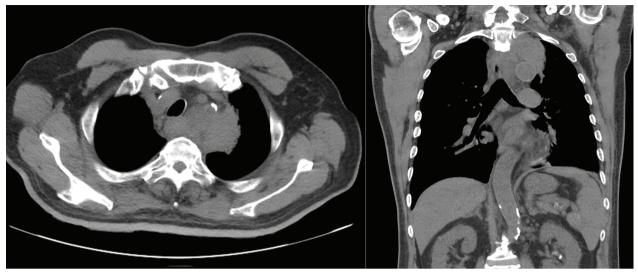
A left upper lobe mass-like lesion as seen on the non-contrast chest computed tomography at the emergency department.
